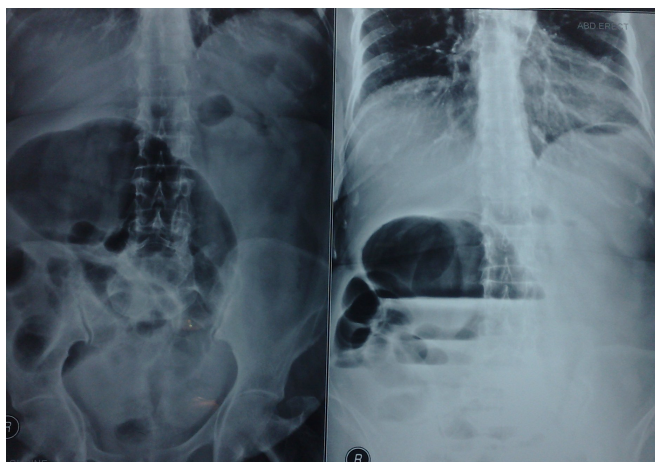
X-ray abdomen-supine (left) and erect showing large air fluid levels
